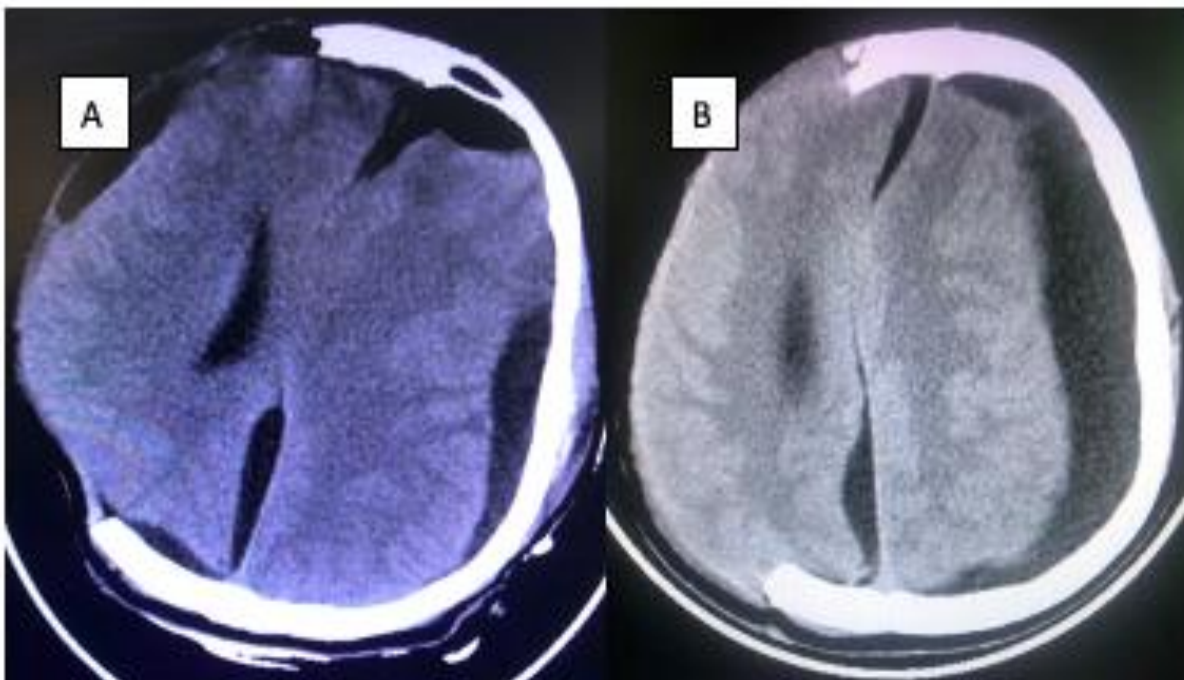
Axial CT scans of the brain taken on POD7, after detecting deterioration in GCS, which showed hygromas in the interhemispheric fissure and under the scalp flap, (A) but mainly on the opposite side of the cranium pushing the brain through the calvarial defect. (B)
